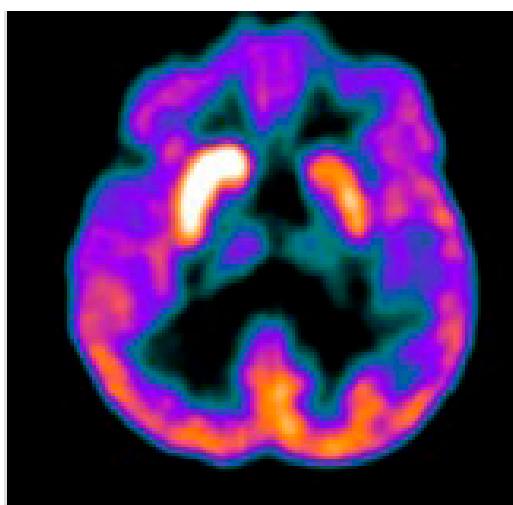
Imagen de estudio de PET-TC cerebral donde se objetiva un aumento focal de la captación de FDG en el lóbulo temporal izquierdo y asimetría en la captación a nivel ganglionar basal ipsilateral.
